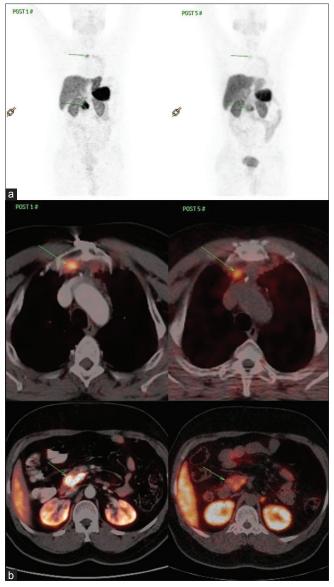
(a) Comparison of 68Ga-DOTATATE positron emission tomography-computed tomography of case 1. (b) Transaxial 68Ga DOTATATE positron emission tomography-computed tomography fused images of case 1
